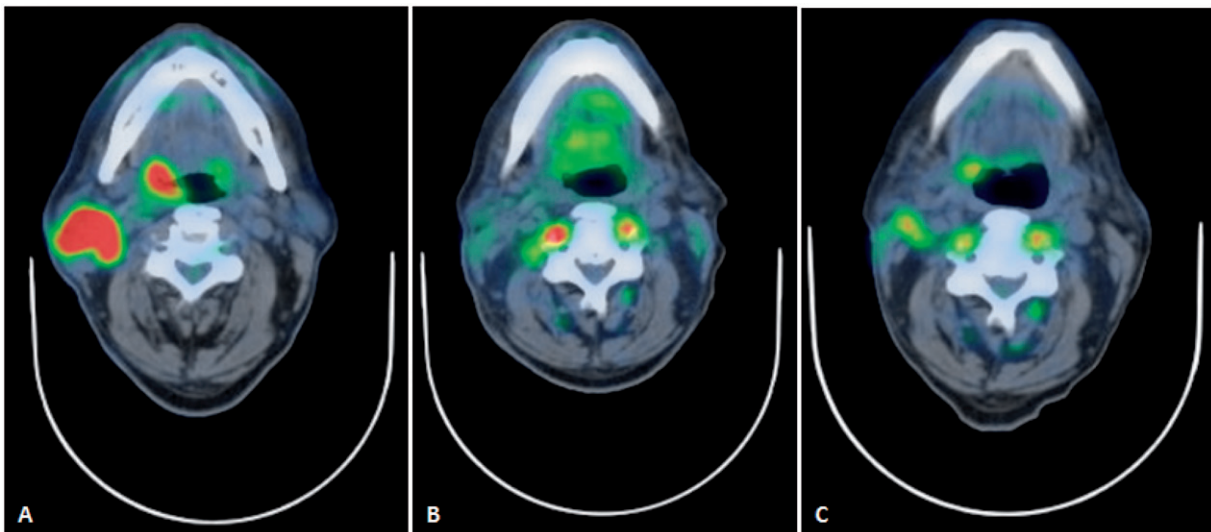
Pre- and post-treatment positron emission tomography-computed tomography axial images. (A) Pre-treatment axial image revealing metabolically active mass of the right tonsil and uptake in the right neck (April 2015). (B) Post-treatment image revealing interval resolution of FDG uptake in the oropharynx and neck (October 2015). (Note: physiological activity in the scalene muscles and oral cavity). (C) Post-treatment image revealing interval increase in FDG activity of right neck and right oropharynx (March 2016).
